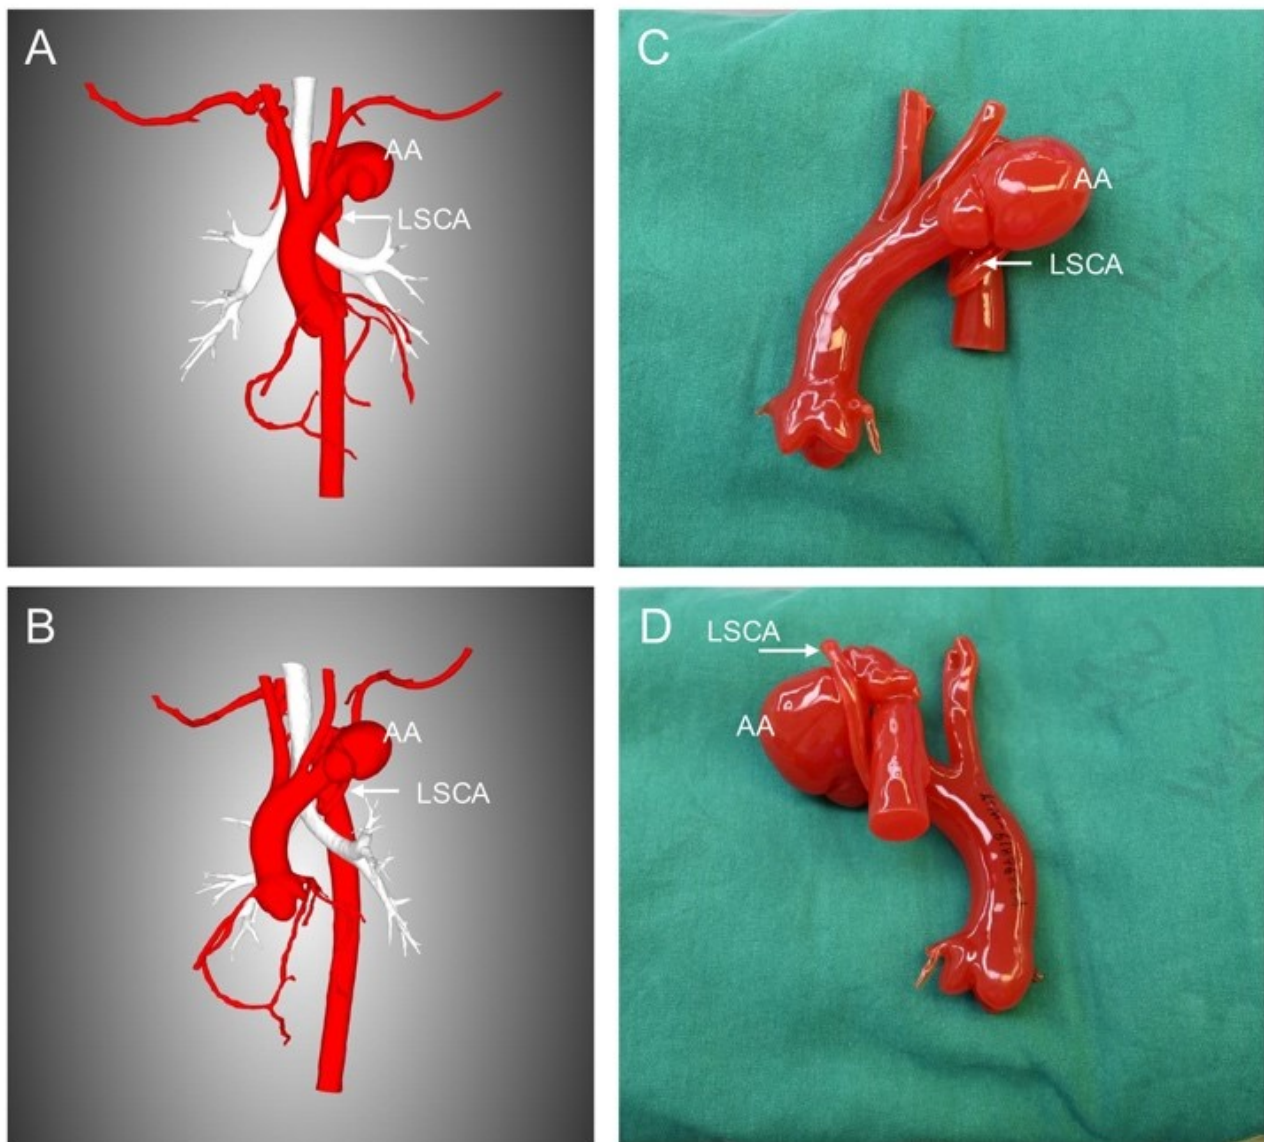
3D CT reconstruction and 3D-printed modeling of the aortic aneurysm. (A) Anterior view of the 3D CT reconstruction. (B) Lateral view of the 3D CT reconstruction. (C) Lateral view of the 3D-printed model. (D) Posterior view of the 3D-printed model. AA, aortic aneurysm; LSCA, left subclavian artery; CT, computed tomography; 3D, three-dimensional.
